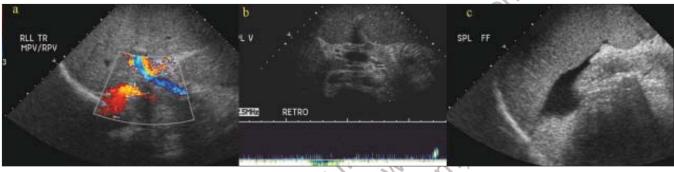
Reversed portal and splenic vein flow. 37 year old with cirrhosis and evidence of retrograde (hepatofugal) flow in portal vein on CDI (a) and splenic vein on spectral doppler (b) as well as splenomegaly and ascites (c).
